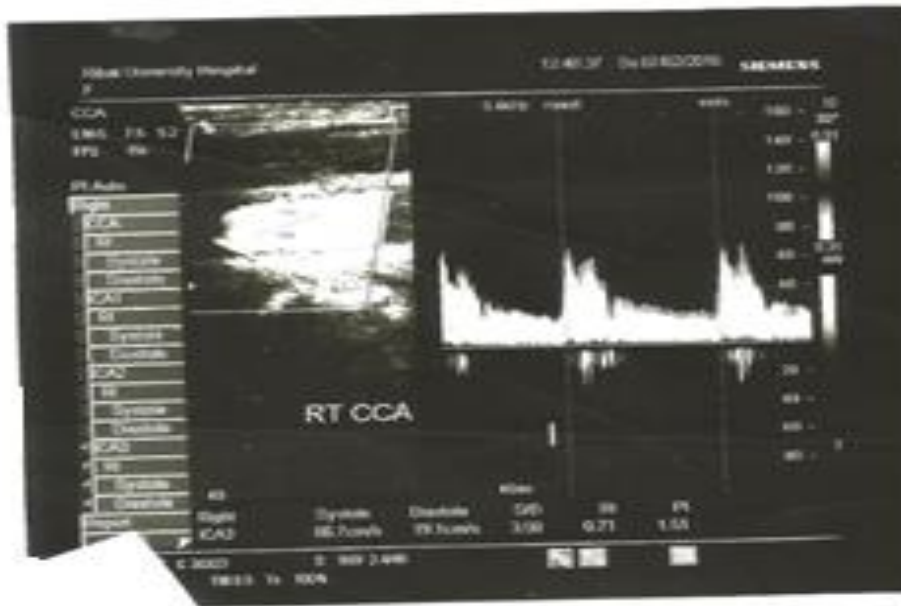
Rt ICA- male- 46 years diabetic patient with normal Doppler parameters.
